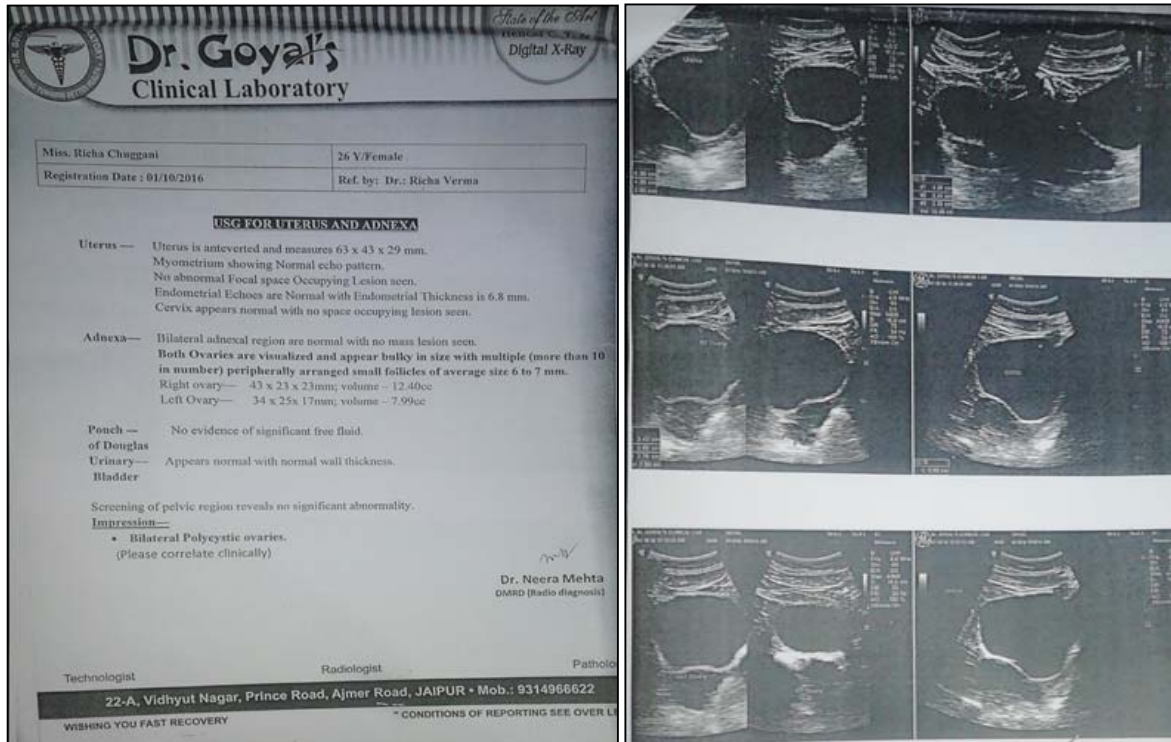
5 Pre - treatment ultrasonography report
